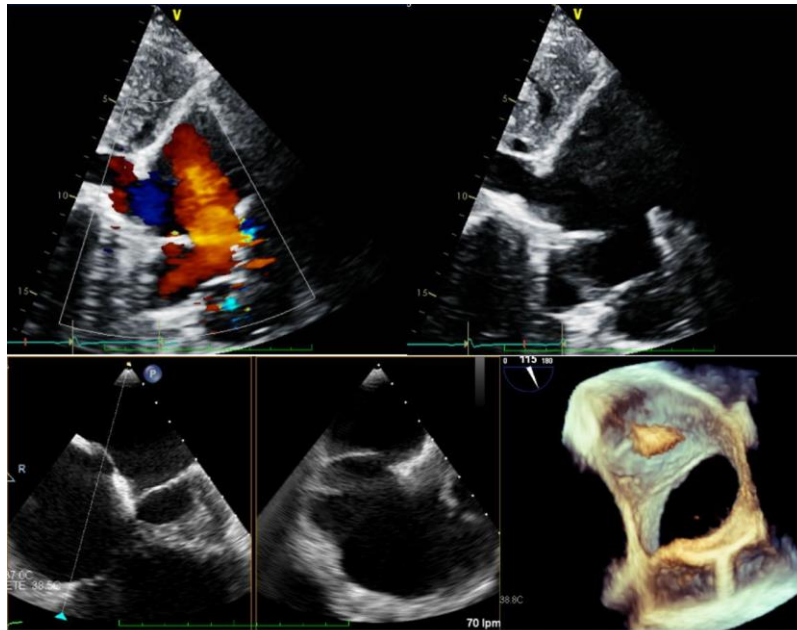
Upper: TTE revealed a sinus venosus atrial septal defect (ASD) with colour Doppler flow with left to right shunt. Lower: TEE with a second atrial septal defect (Ostium secundum) and 3D reconstruction of the sinus venosus ASD.
